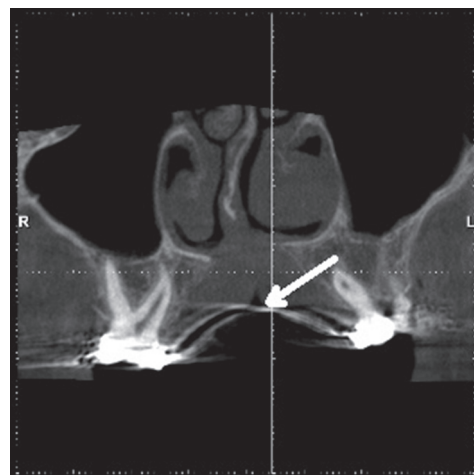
Postoperative cone beam coronal computed tomography after 3 months demonstrating a cul-de-sac depression (white arrow)
